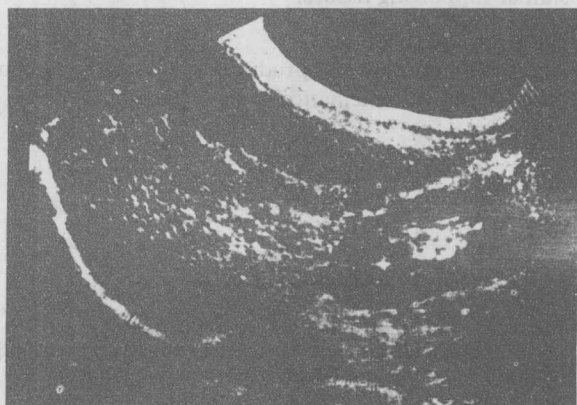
Gray scale B-mode ultrasonogram through right lobe of the liver and kidney showing marked improvement in resolution and display of tissue consistency when echoes of various amplitudes are displayed in different shades of gray.
